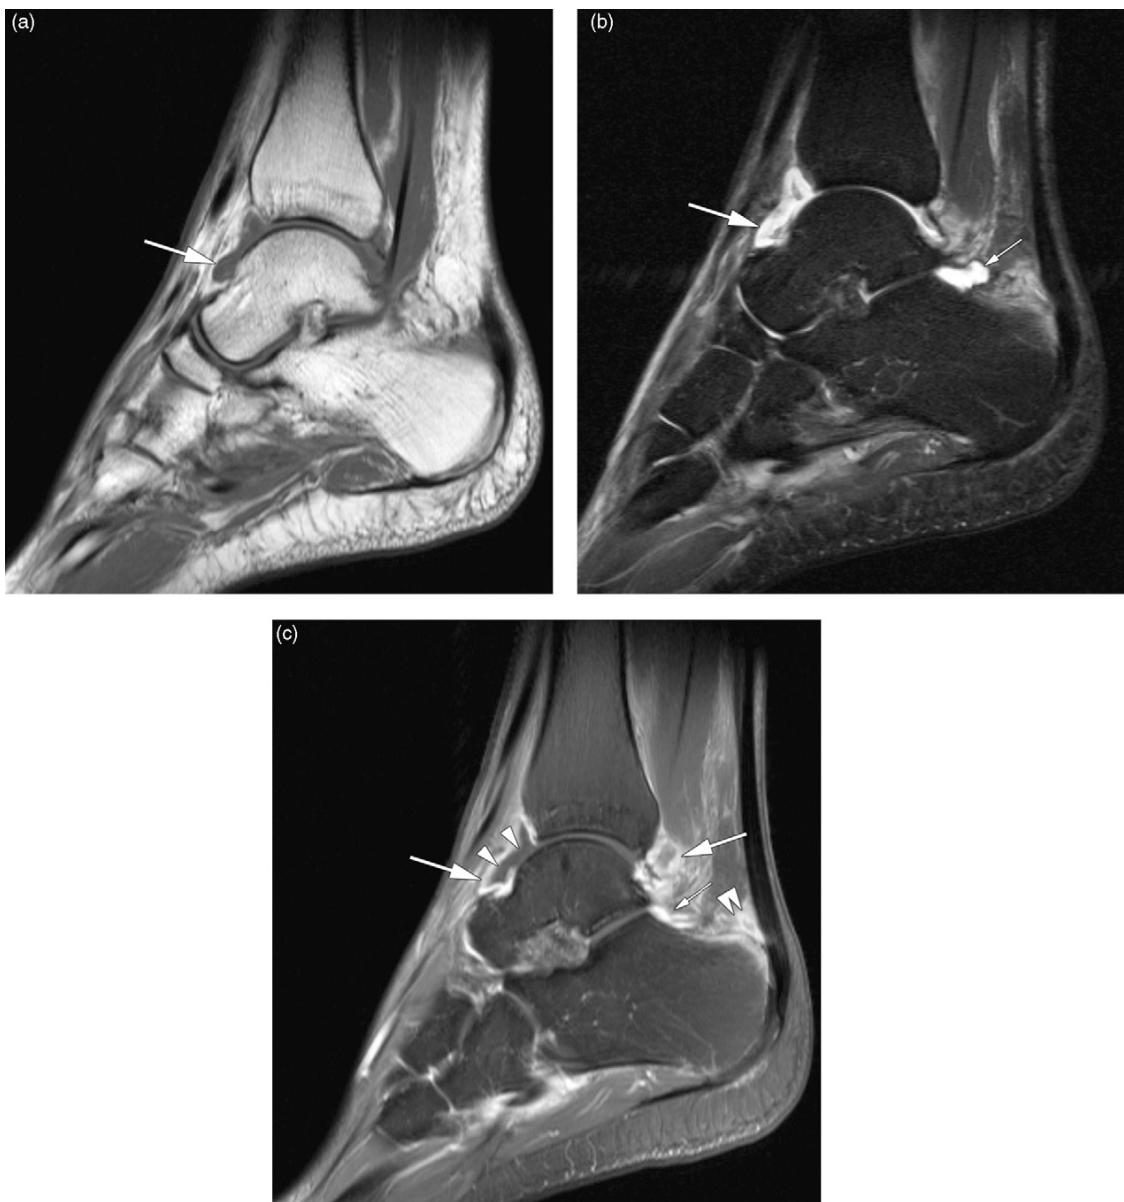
1.5 T MRI of the ankle in a 33-year-old patient with reactive arthritis. Unenhanced sagittal T1-weighted turbo spin-echo (a), and STIR sequences (b) as well as fat-suppressed T1-weighted turbo spin-echo sequence after contrast injection (c) show tibio-talar synovitis (large arrows) and talo-calcaneal synovitis (small arrow). Contrast injection allows for the differentiation between synovitis and effusion (arrowheads). In addition, retrocalcaneal bursitis (double arrowheads) and discrete calcaneal bone marrow edema are seen.
